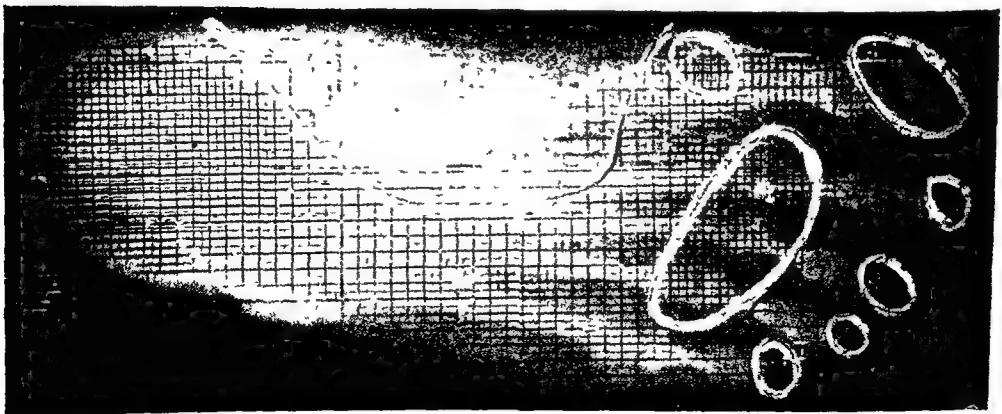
ORTHODYNAMIC RADIOGRAPH (X-RAY PAPER) High arch foot type excess imprint to metatarsophalangeal joints, medial sesamoid, and distal areas of toes
